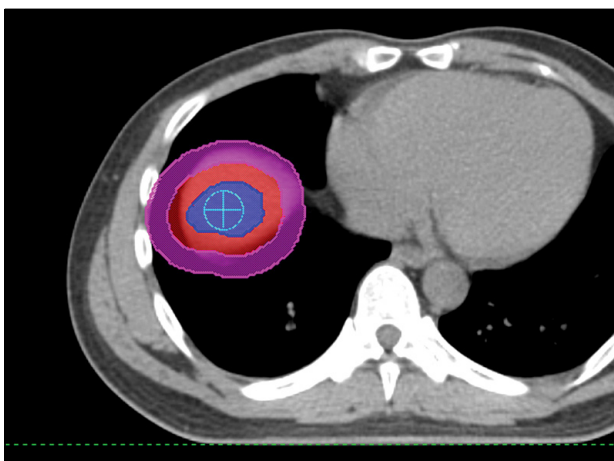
An axial CT image of the patient. The cross denotes the isocenter of the beam. The blue does a virtual GTV (a vir_Lung_GTV), the red a virtual PTV (a vir_Lung_PTV), and the pink a virtual ROI (a vir_Lung_Ring).
